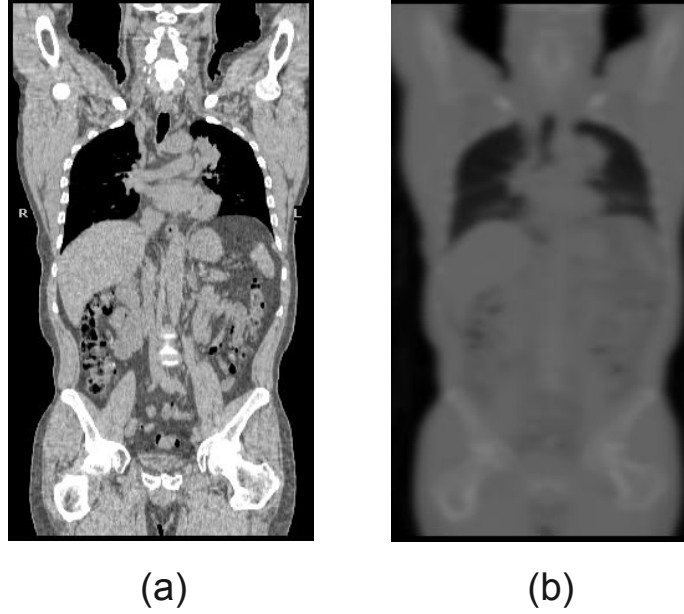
Helical CT image (a) and the corresponding CT attenuation correction map (b). The CTAC has been spatially filtered and transformed to μ_{511} values.
